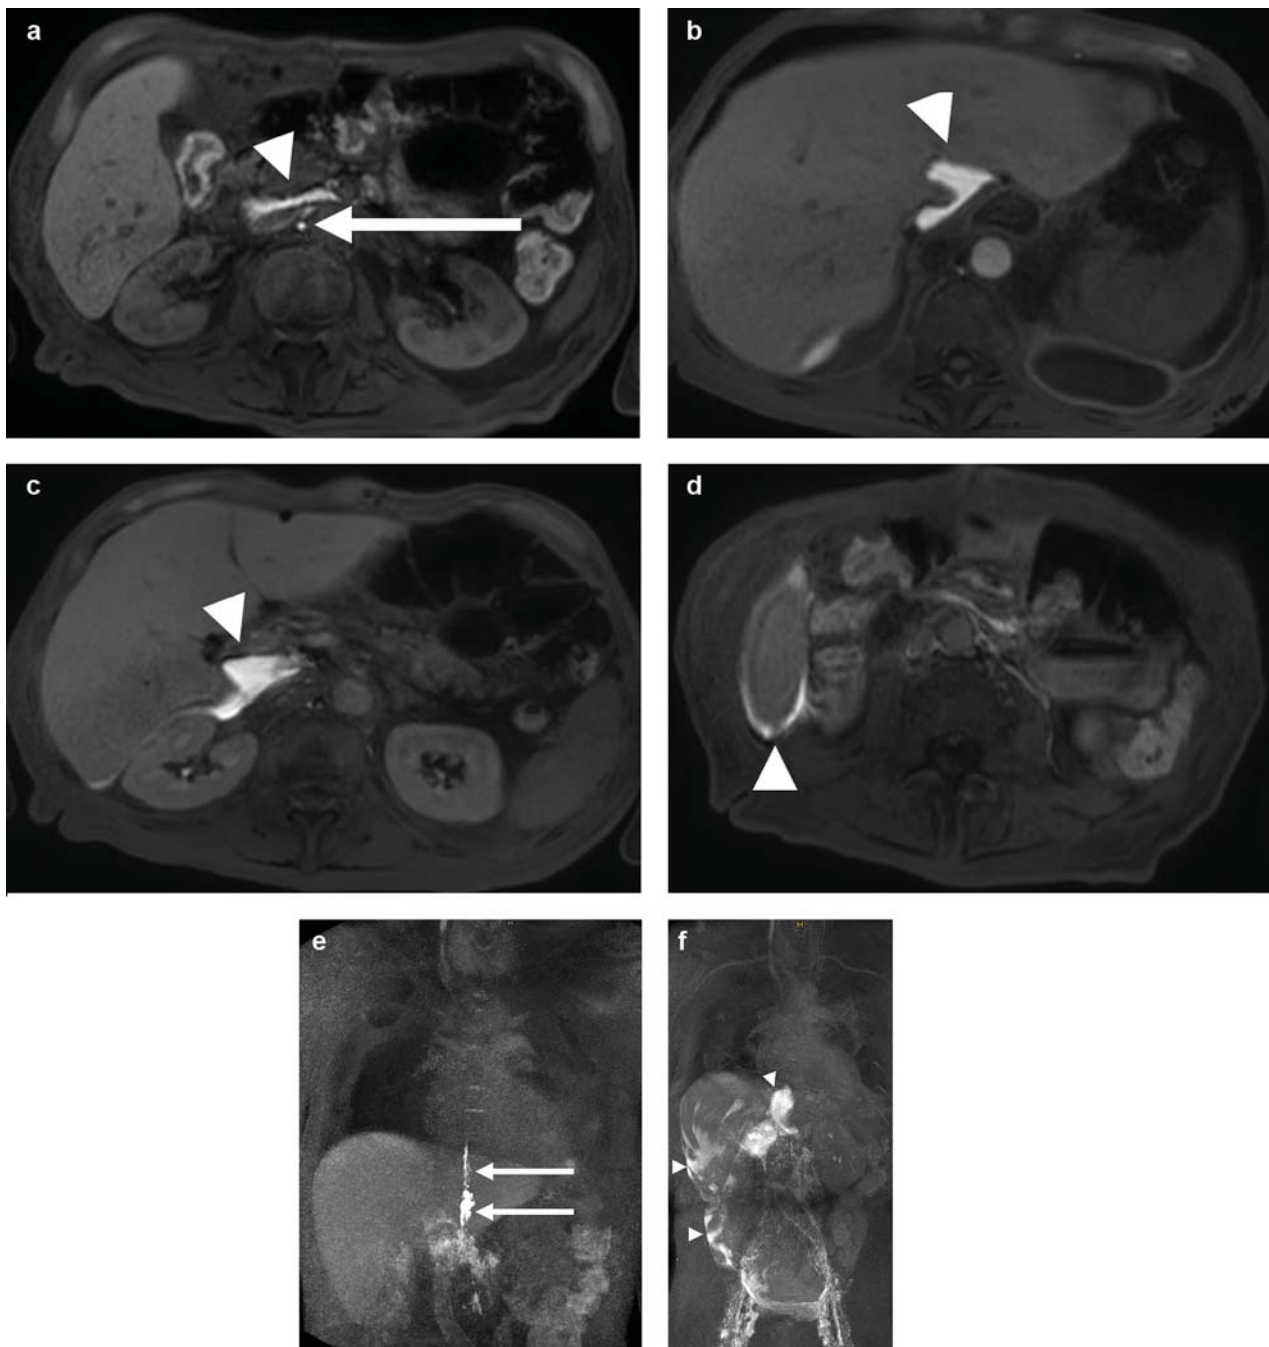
Interstitial transpedal MRL of a 59-year-old patient with therapy refractory chylous ascites after esophagectomy. (a–d) Axial slices and (e, f) coronal MIP reconstruction of T1-weighted MRL after contrast application showing enhancement of the cisterna chyli and the thoracic duct (arrows) with complete transection of the thoracic duct in the upper abdomen as the cause of chylous ascites. There is consecutive massive extravasation of contrast into the abdominal cavity with enhancement of the ascitic fluid on late images (arrow heads on a–d and f).
